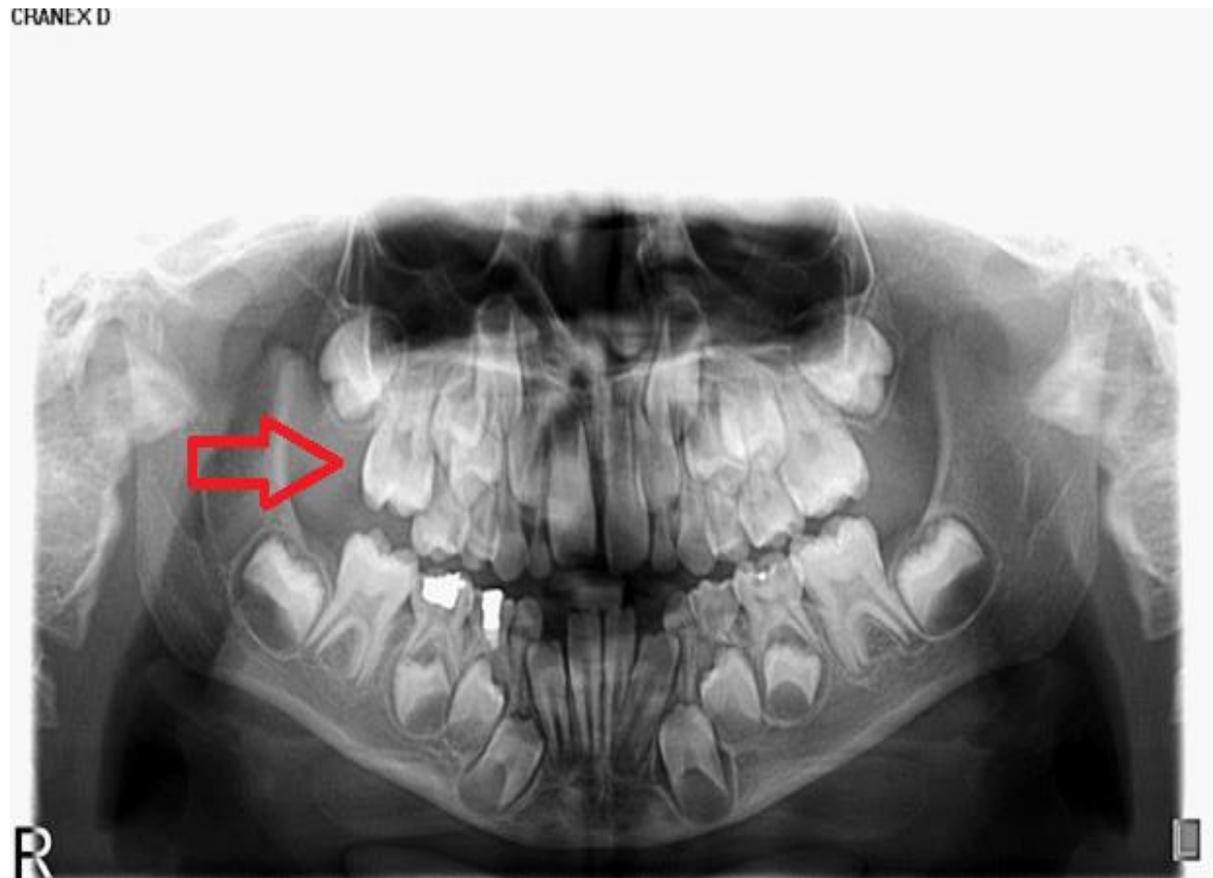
Panoramic Radiograph, which shows the ectopic eruption of the right permanent maxillary first molar. (R=right, L=left).
